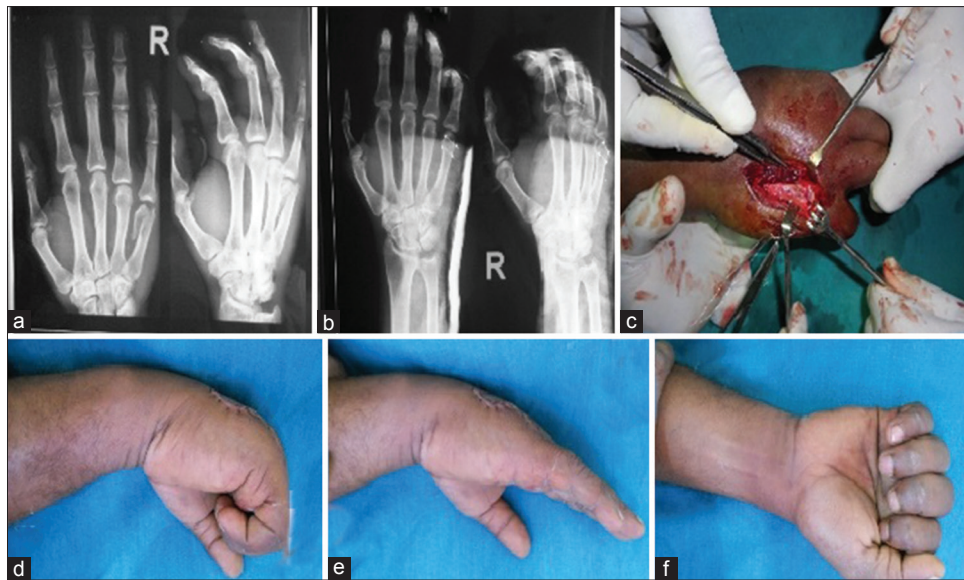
(a) X-ray of the hand anteroposterior and lateral views showing fracture of neck of the 5th metacarpal (b) Postoperative X-ray of the same patient showing fixation with two bone ties (c) Peroperative photograph showing fixation with bone ties (d-f) Clinical photographs showing range of motions
